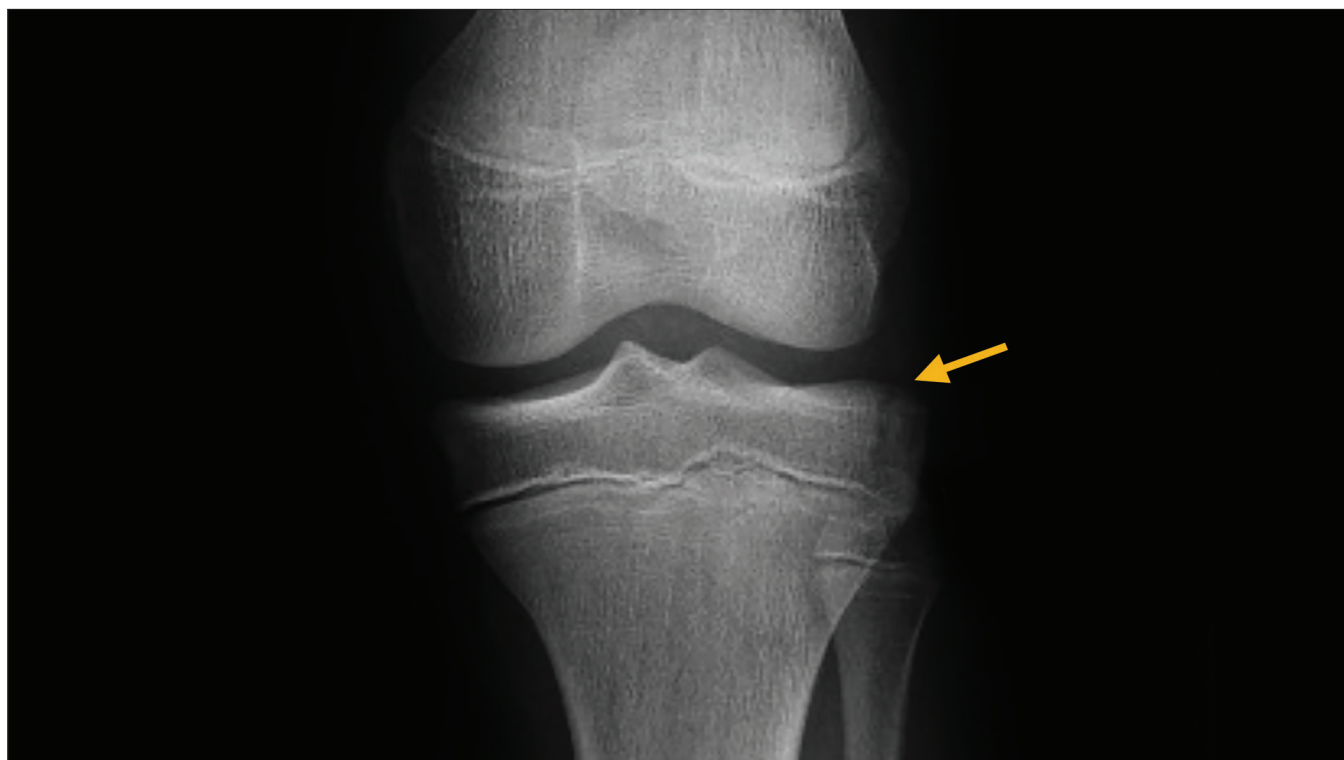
Anteroposterior radiograph of the left knee demonstrating an intra-articular, nondisplaced Salter-Harris type III fracture (arrow) of the left lateral tibial plateau.
